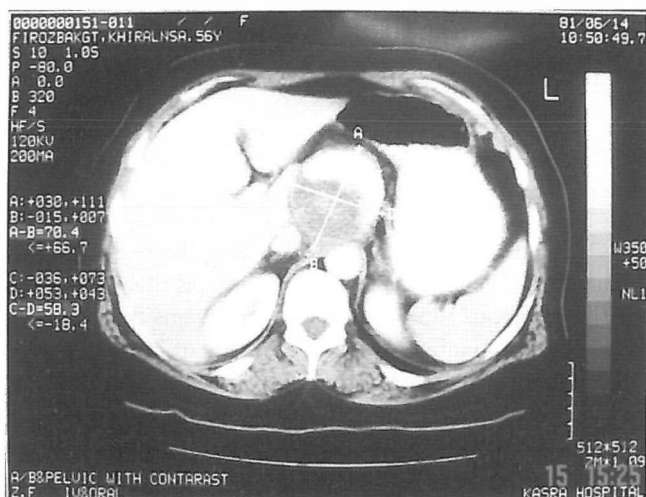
CT scan showing a 5.5 cm round mass in the upper part of the abdomen.
